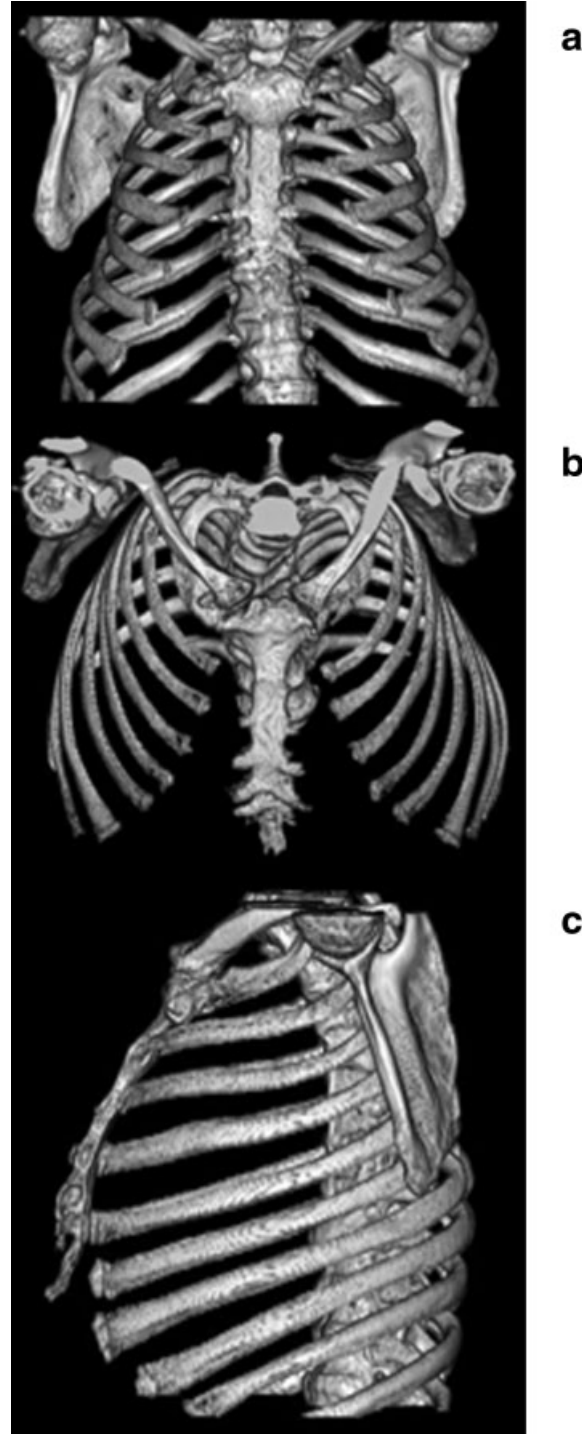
CT reconstruction of the rib cage in a LS patient. Note: a) the funnel-shaped appearance of the thorax, b) the orientation of the ribs: supero-internal to infero-external plane, c) the deep rib cage.
